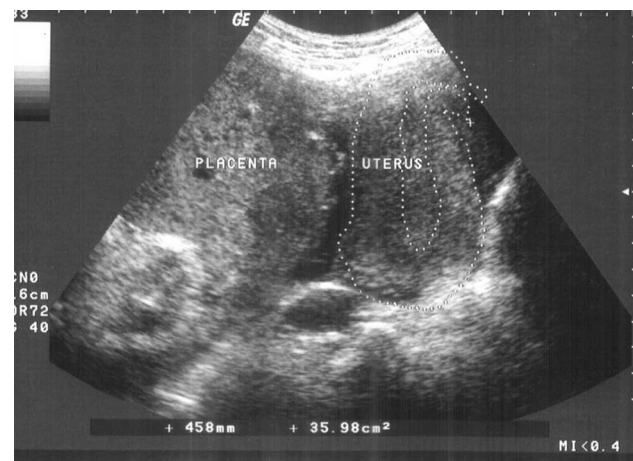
Grey scale ultrasound picture showing empty uterus and placental implantation outside uterus
